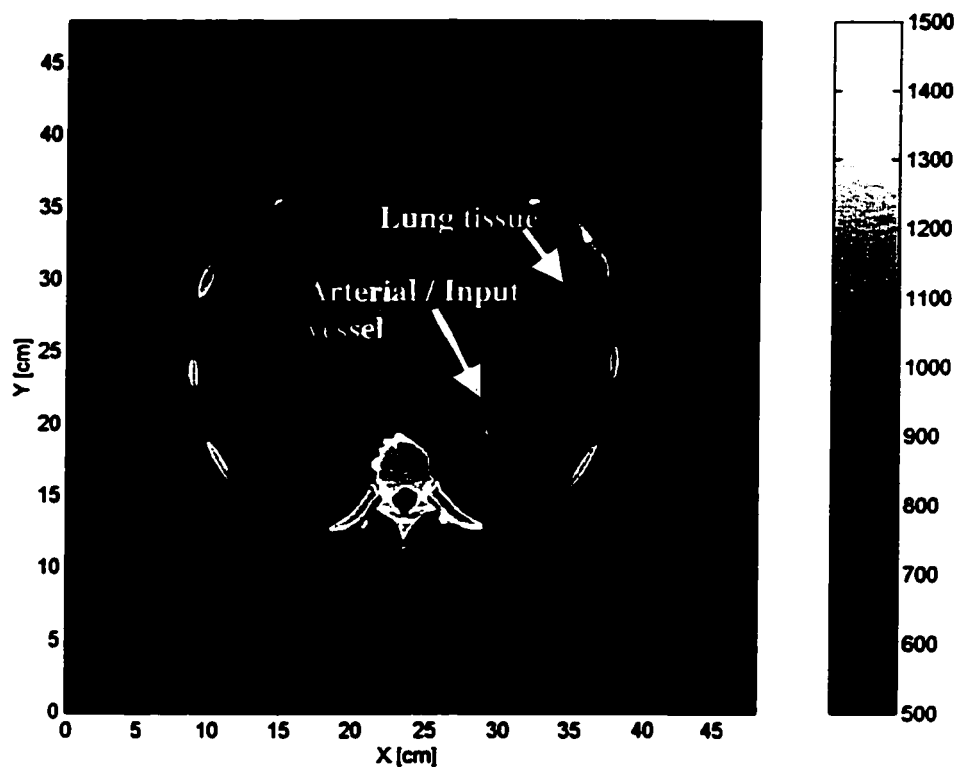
A CT image of the patient during the dynamic CT procedure.
